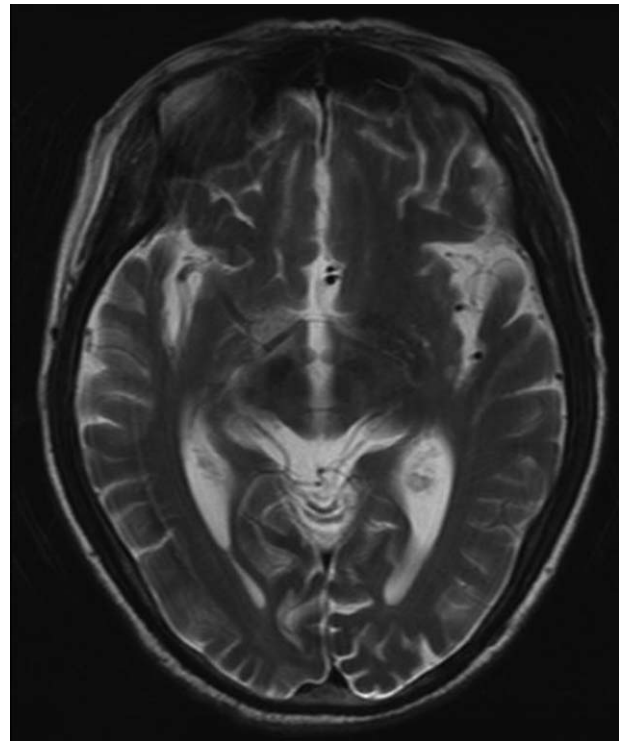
Cerebral magnetic resonance imaging showed lacuna infarctions.
